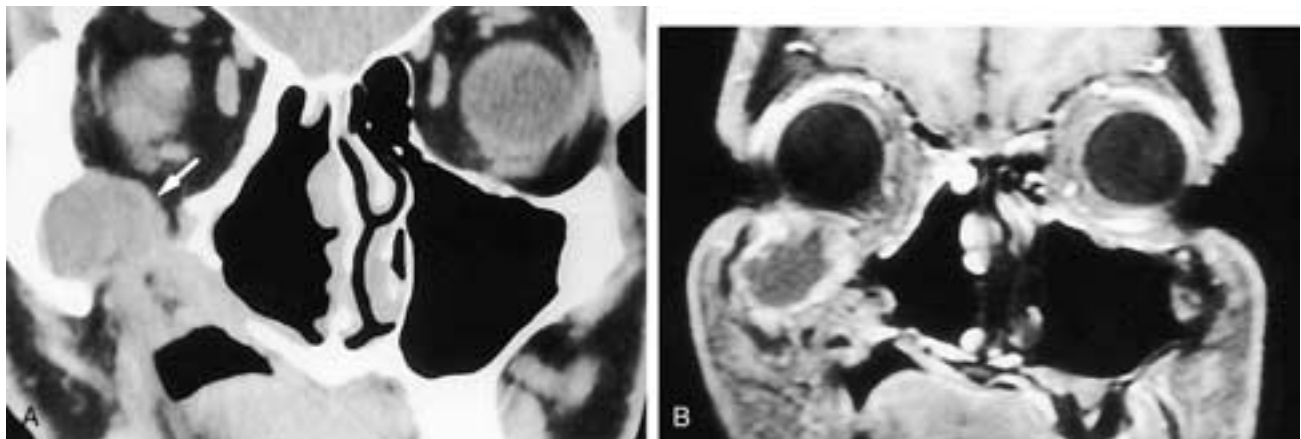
Coronal CT (A) and coronal T1-weighted, contrast-enhanced, fat-suppressed MR (B) image show a patient's status after an extended right lateral rhinotomy. No nodularity is present within the postoperative cavity. However, there is a mass (arrow in A) in the right zygomatic recess of the right antrum, which has broken into the floor of the right orbit. The lesion has surrounding mucosal enhancement, but the secretions within it do not enhance. This patient had a postoperative mucocoele.
